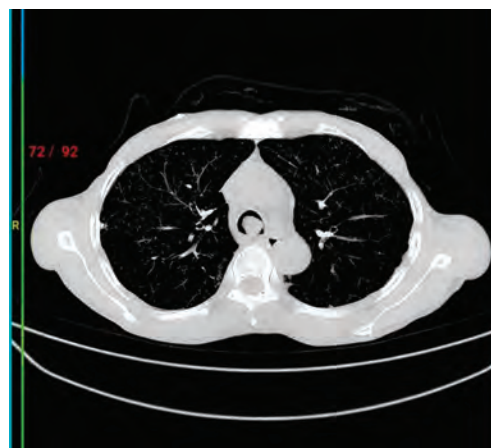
CT chest showing an intraluminal mass arising from the posterior tracheal wall
